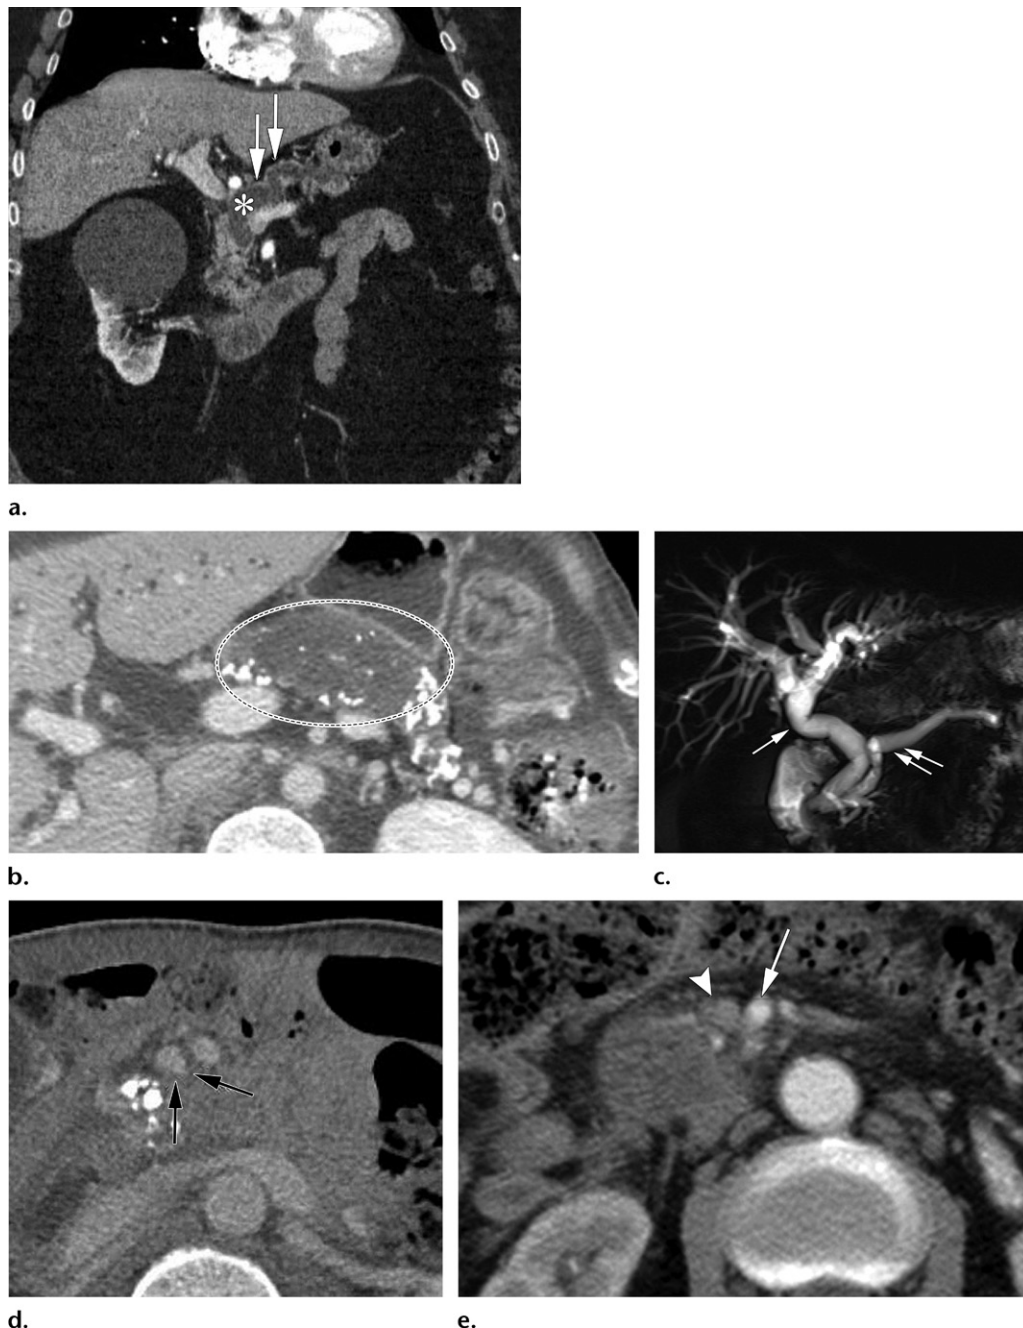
Imaging findings that favor diagnosis of a malignancy rather than an inflammatory condition. (a) Coronal CT image shows a duct-to-pancreas ratio (maximum diameter of the diffusely dilated main pancreatic duct [*] and the overlying atrophic parenchyma [arrows]) of greater than 0.5. (b) Axial CT image shows diffuse calcifications in the background parenchyma and peripheral displacement of calcifications by a focal hypoattenuating lesion (dotted circle) in the pancreatic body. (c) MR cholangiopancreatogram shows the double duct sign, or dilatation of both the pancreatic duct (double arrows) and the common bile duct (single arrow). (d) Axial CT image shows the teardrop sign (arrows), a teardrop-shaped deformity of the SMV due to vascular encasement. Note the loss of fat in the perivascular space. (e) Axial CT image shows the SMA-to-SMV ratio, or the decreased caliber of the SMV (arrowhead) (almost the same size as the SMA [arrow]), of greater than or equal to 1.0. Note the loss of fat in the perivascular space.
